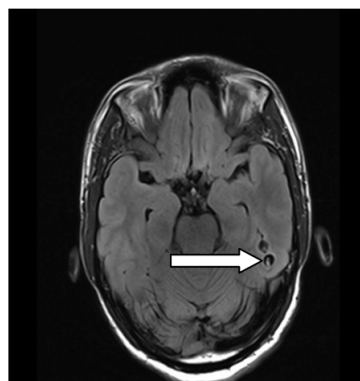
MRI-FLAIR axial non-contrast
